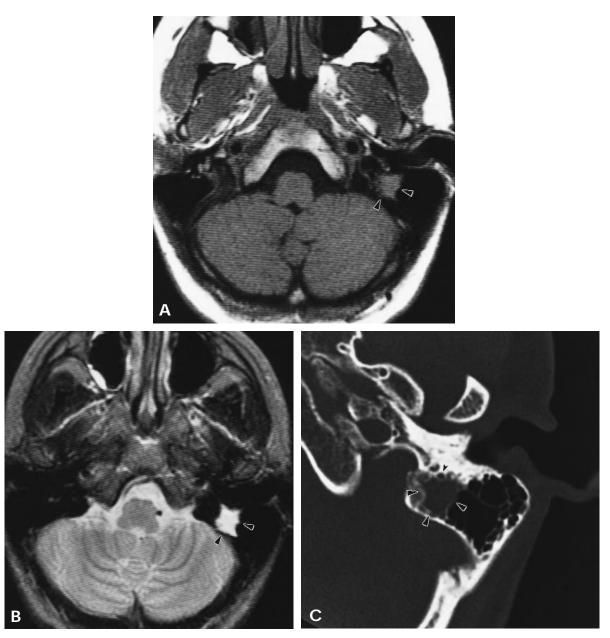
A, T₁-weighted pregadolinium MRI depicting isointense left mastoid lesion (*arrows*). B, T₂-weighted pregadolinium MRI of same lesion (*arrows*) demonstrating hyperintense signal intensity. C, Temporal bone CT scan demonstrating mastoid lesion (*outlined arrows*) abutting fallopian canal (*smaller solid arrow*).
